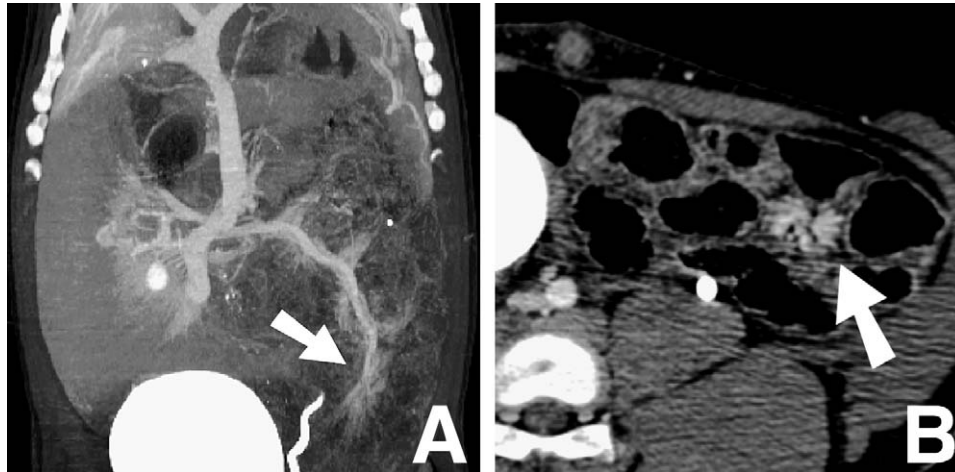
Venous dilatation (*white arrows*) noted in coronal (A) and axial (B) images by M.D.CT-CTA (postcontrast injection) at the site of arterial occlusion, indicating ischemia.
